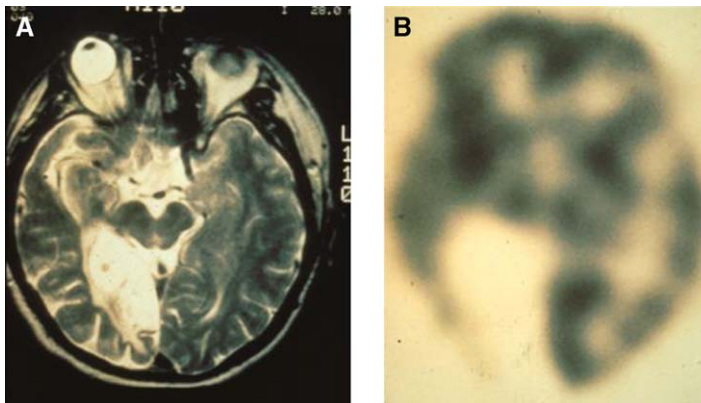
(A) Patient with a history of right temporal lobe astrocytoma status post-radiation therapy presenting with worsening symptoms and an MR imaging abnormality that could not be categorized as either radiation necrosis or recurrent tumor. (B) FDG-PET scan demonstrates hypometabolism in the same region with no foci of increased activity where the MR imaging abnormality was noted. This finding indicates that there is radiation necrosis and no evidence of recurrent tumor.
